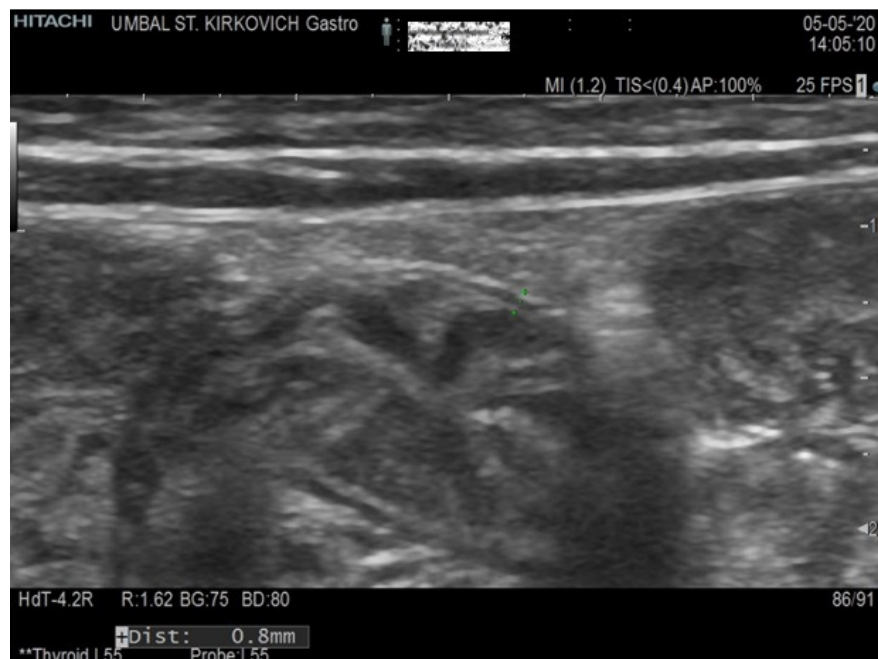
Abdominal ultrasound during the hospitalization.
